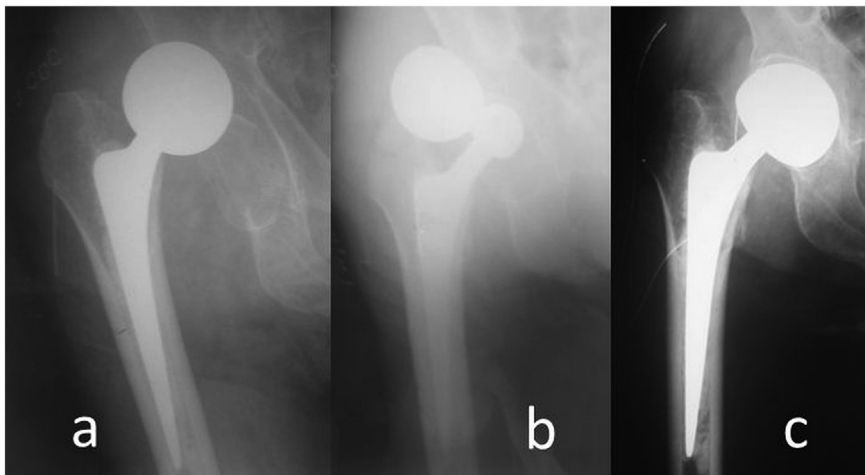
(a) Case 2: Plain roentgen showing posterior dislocation of the hip. (b) Case 2: Plain radiograph showing dissociation between bipolar cup components after reduction maneuvers. (c) Case 2: Postoperative appearance after revision of the bipolar cup.
